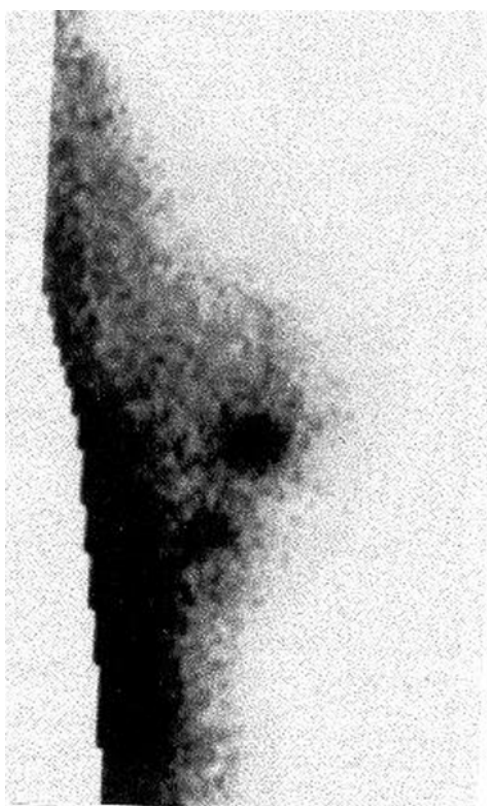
In the scintimammography performed with ^{99m}Tc -sestamibi, two breast lesions due to ductal carcinoma are seen at the lower part of the right breast. Microcalcifications were seen in the X-ray mammography.
